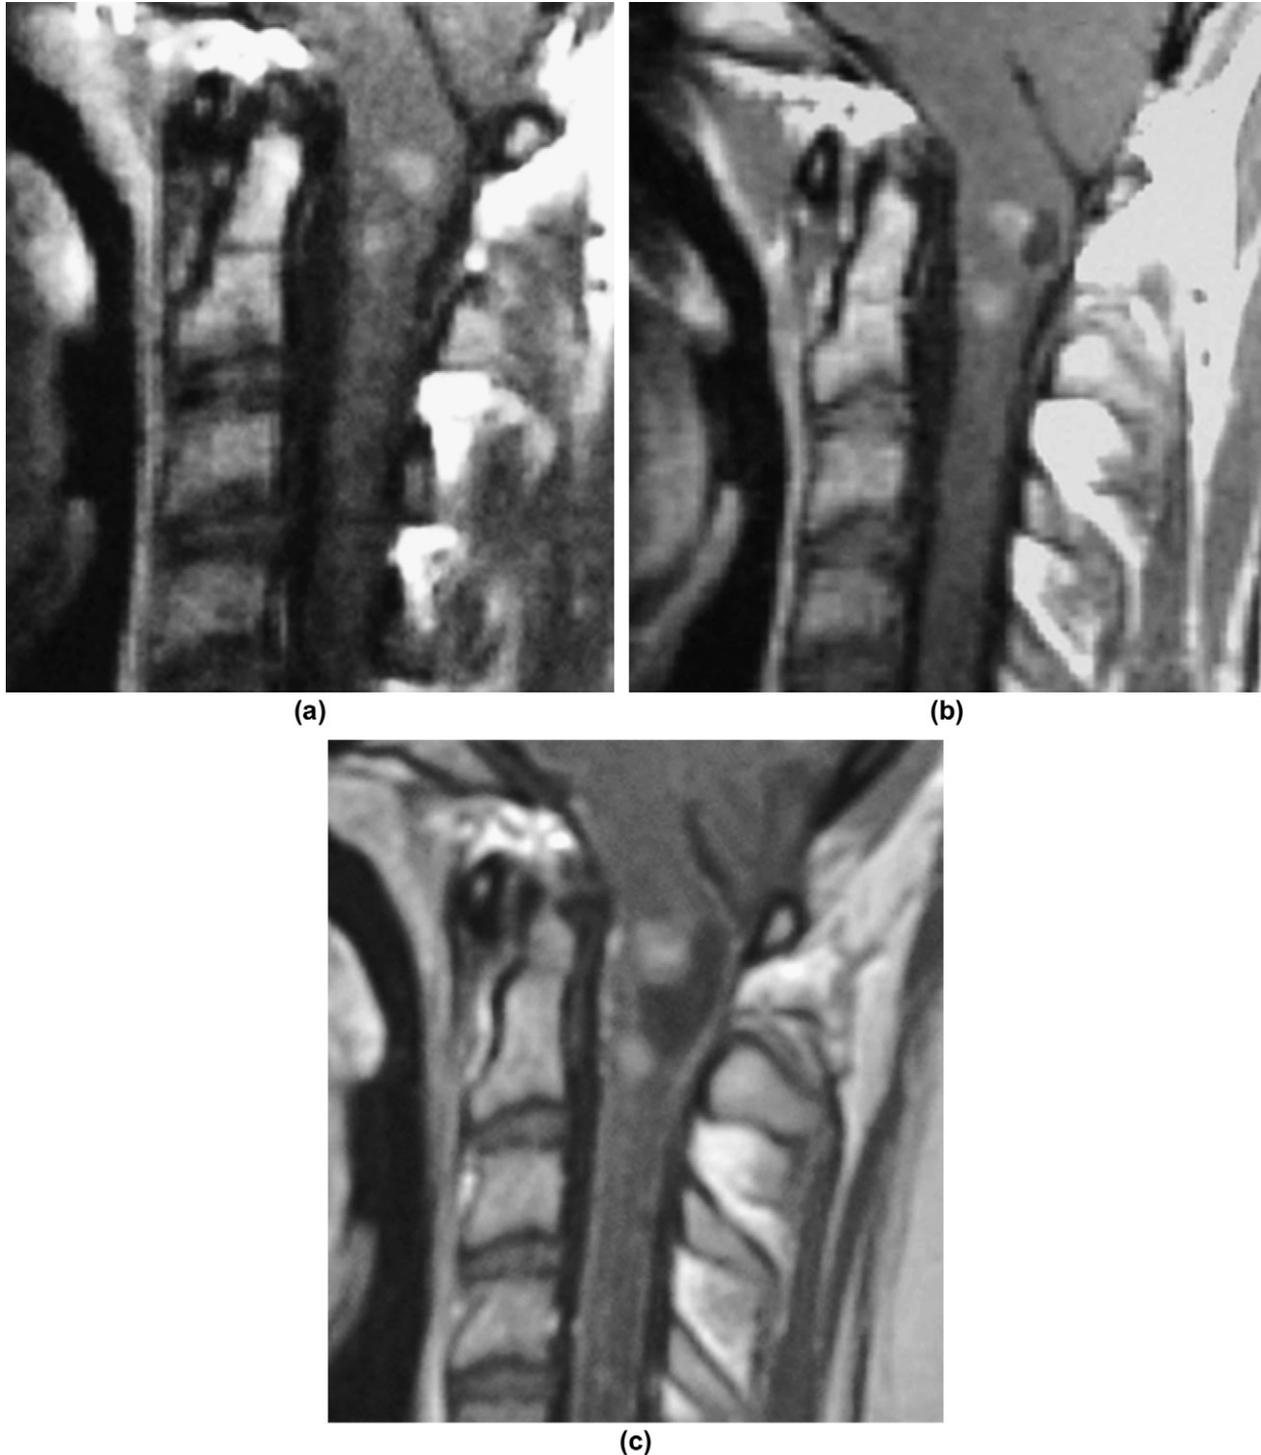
Patient 8: A sagittal T2-weighted image (a) shows multiple intramedullary nodules within the cervical cord. The highest lesion is at the level of the obex. The low signal, extramedullary lesion at T2/3 was a meningioma. A sagittal T2-weighted image of the same patient performed 7 years later (b) demonstrates no change in the intramedullary lesions. The patient has undergone surgery to remove the meningioma.
